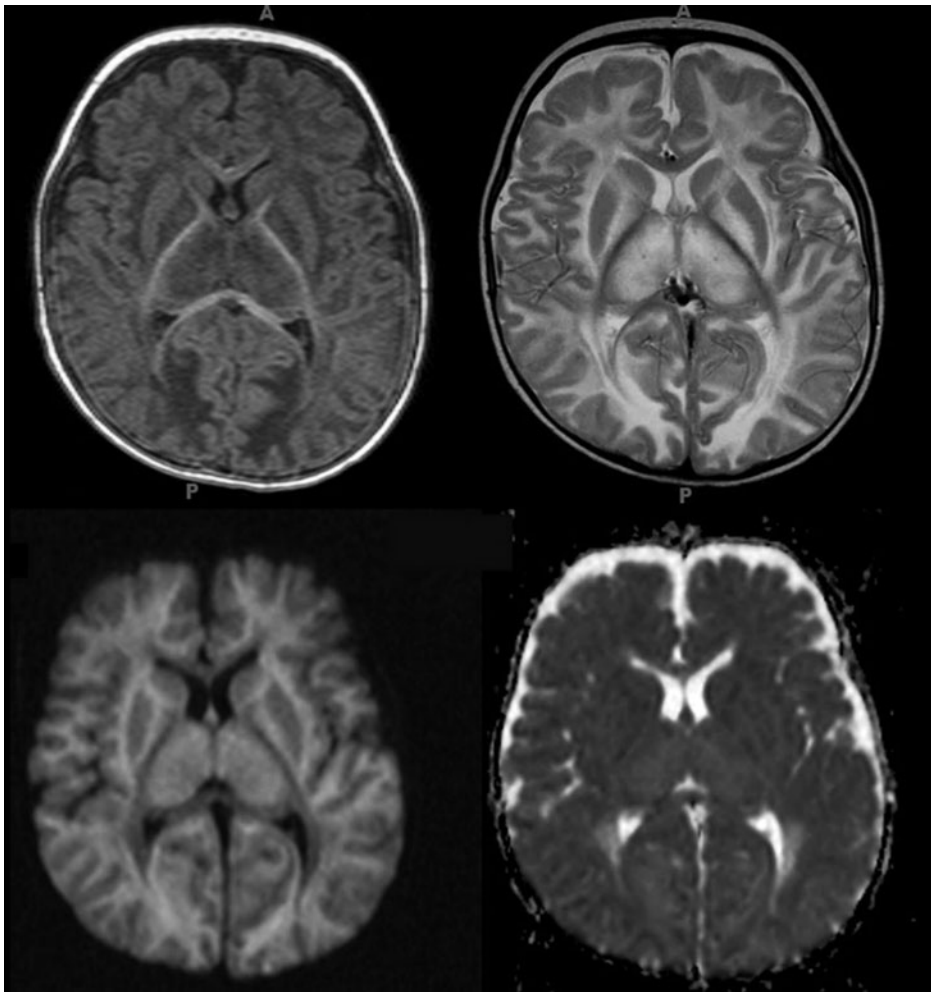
A 7-month-old boy with Canavan disease. Brain MRI T1-MPR (upper left) and T2 sequences (upper right) show diffuse signal abnormality throughout the bilateral cerebral white matter. Trace-diffusion (lower left) high signal and low ADC on the ADC map (lower right) indicate diffusion restriction within these regions. Note the preservation of myelin within the posterior limbs of the internal capsules and the corpus callosum.
